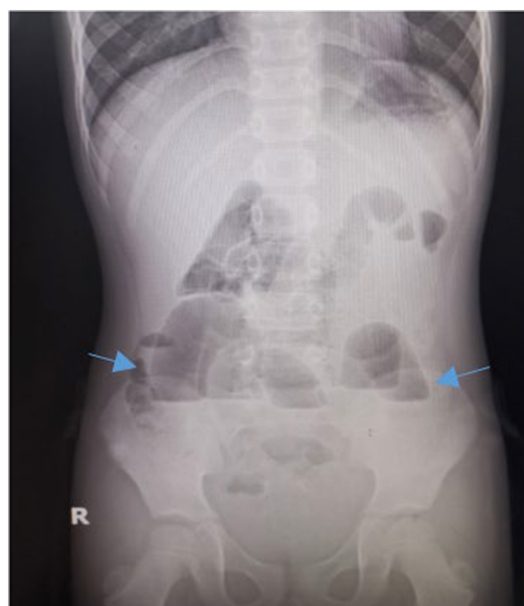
Unprepared abdomen x-ray: air fluid level (blue arrow).
